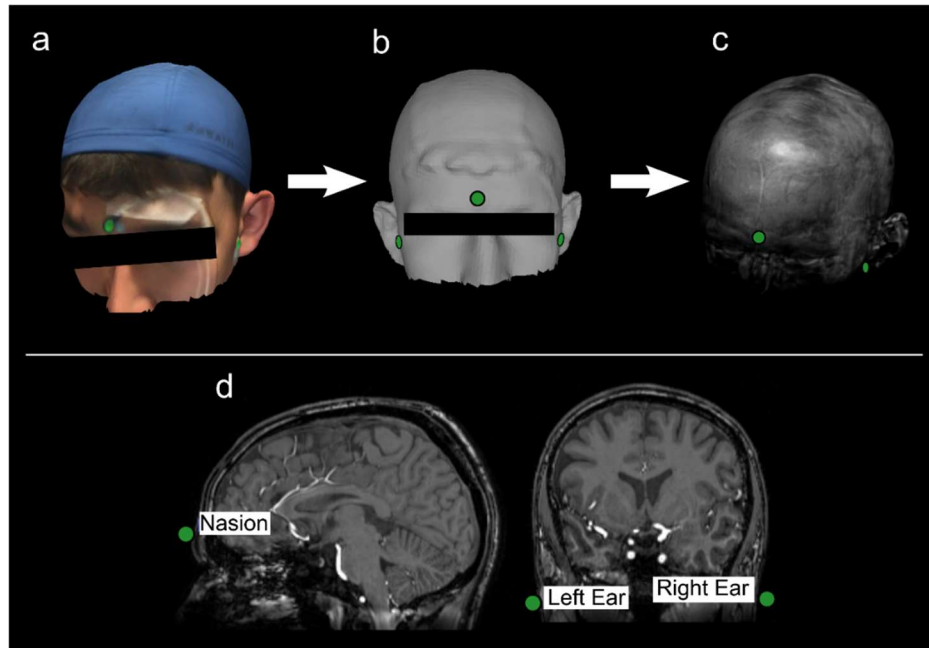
Coregistration procedure for conventional MEG. Three fiducial coils (green dots), which are enegised during the recording and can thus be localised by the MEG scanner, are attached to the nasion and preauricular points. a) A scan using a 3D optical imaging system, or head digitisation using a POLHEMUS digitiser is used to create a 3D representation of the head shape and the relative positions of the fiducial coils (b). This shape is coregistered to the scalp (c)—extracted from an anatomical MRI—using an iterative closest point algorithm, yielding the positions of the fiducial markers relative to the brain anatomy as shown in (d).
